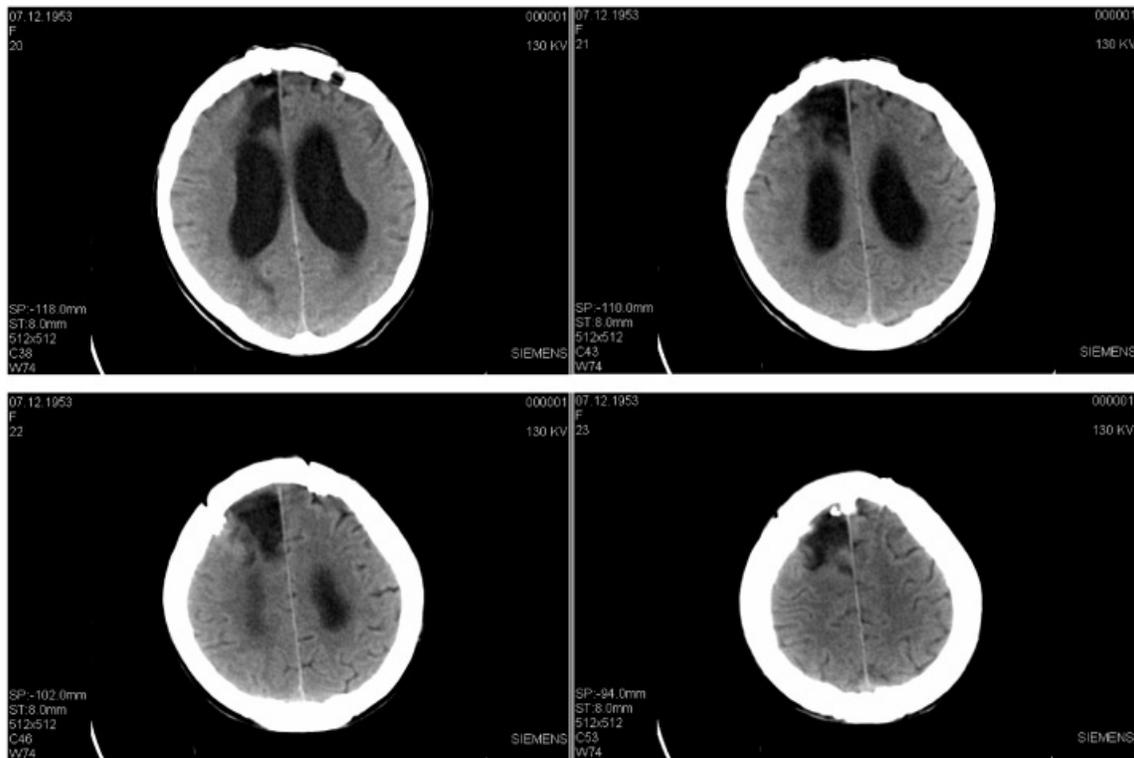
CT-scan (horizontal slices) of Patient DG.
